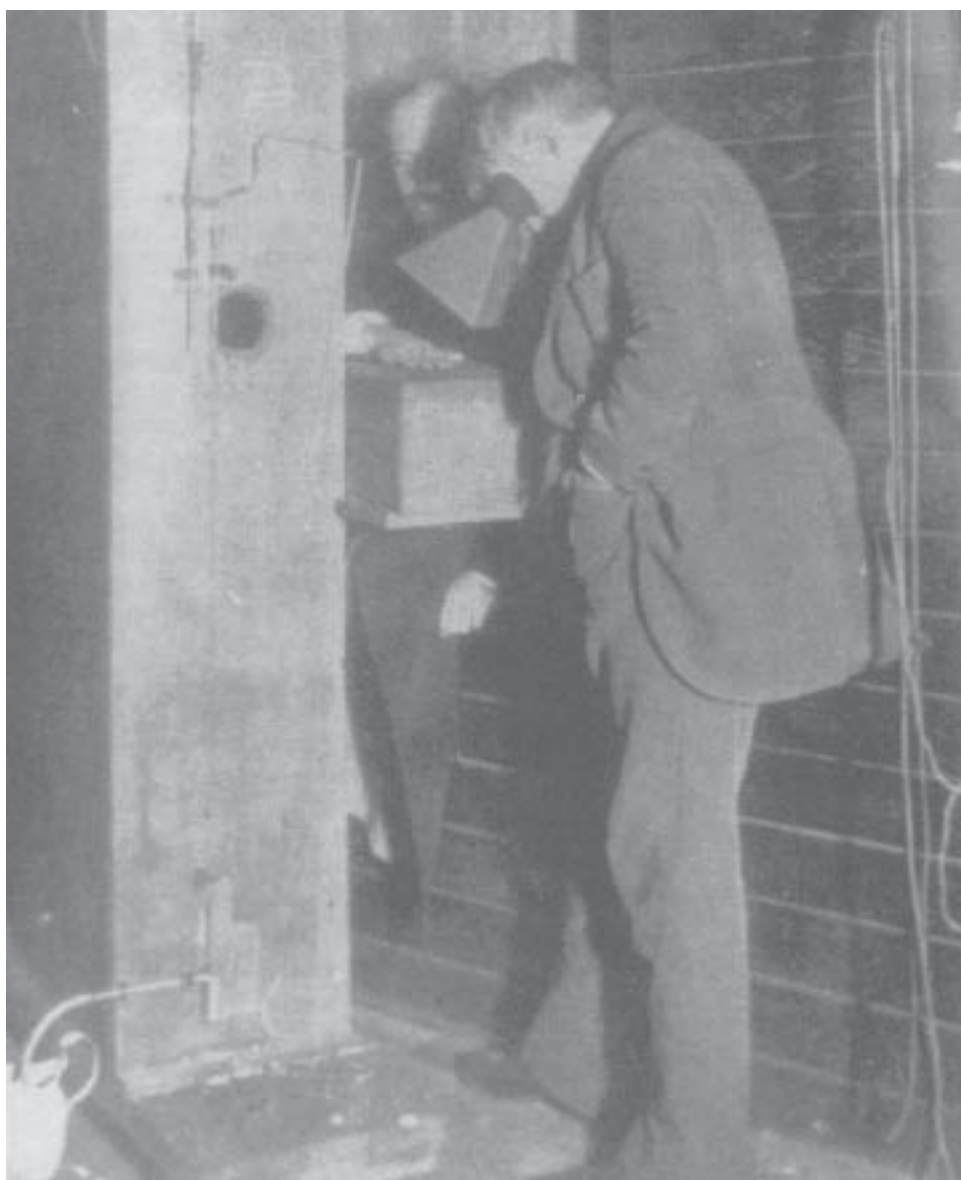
Thomas Edison looks through the fluoroscope; his subject is his assistant Clarence Dally, who died in 1904 as a result of his frequent exposure to X rays. Reprinted from Feldman A. A sketch of the technical history of radiology from 1896 to 1920. *RadioGraphics*. 1989;9(6):1113–1128. Photograph: Courtesy of Arnold Feldman; Department of Radiation Oncology; Methodist Medical Center; Peoria, Ill.
